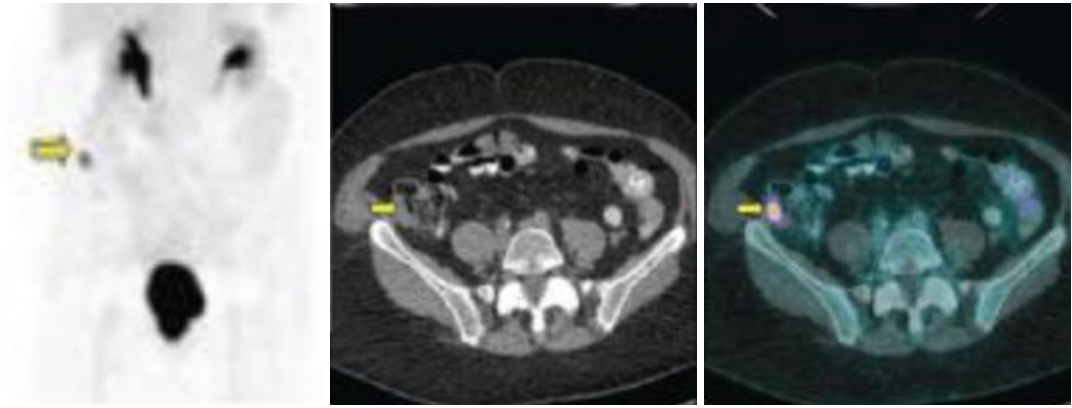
Staging of non-small cell lung cancer. FDG image (*left side*), CT images (*middle*), and fused images (*right image*) in PET-CT show apart from the primary tumor (not shown here) incidental right iliac fossa a small
